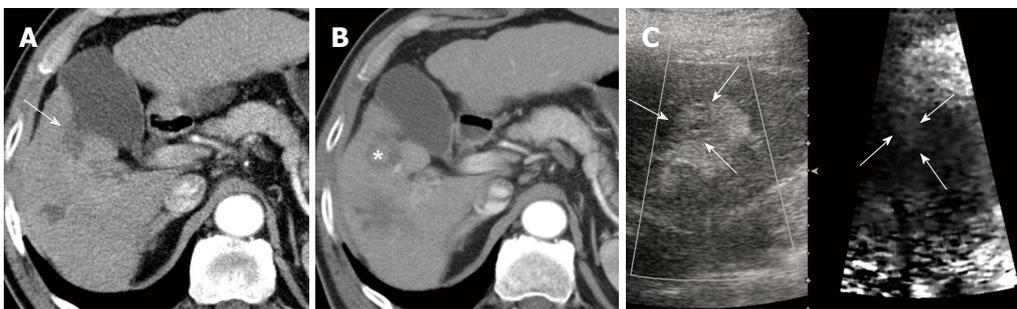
Recurred hepatocellular carcinoma after radiofrequency ablation in a 65-year-old man with underlying liver cirrhosis. A: Follow-up post-radiofrequency ablation (RFA) computed tomography (CT) scan shows the ablation zone of low attenuation without residual or recurrent tumor in segment 5 of the liver (arrow); B: Contrast-enhanced CT scan obtained after 6 mo shows enhancing nodule in the ablated lesion (asterisk). The serum alpha-fetoprotein increased from 2.6 ng/mL to 16.8 ng/mL; C: On a B-mode image, prior RFA site and recurrent hepatocellular carcinoma (HCC) are seen as homogeneous hyperechoic lesions and subtle heterogeneous echogenic nodules with a thin hypoechoic rim (arrows). The recurrent HCC appears as a brighter color (softer) with a distinct border on the acoustic radiation force impulse image.
